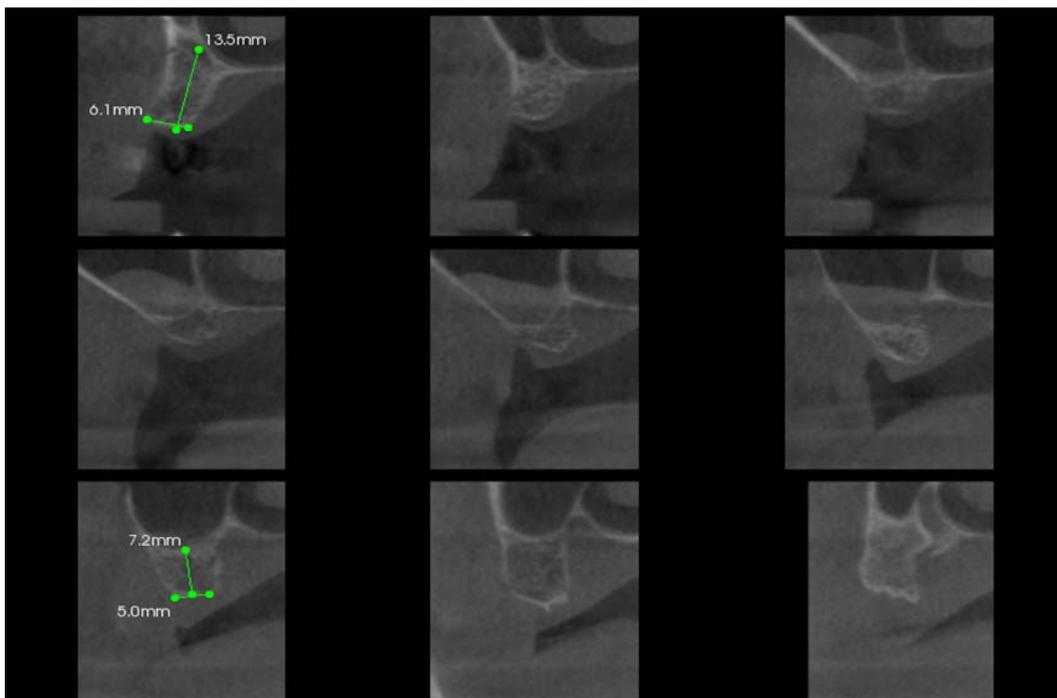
Different sections on volumetric 3D CT-CBCT
